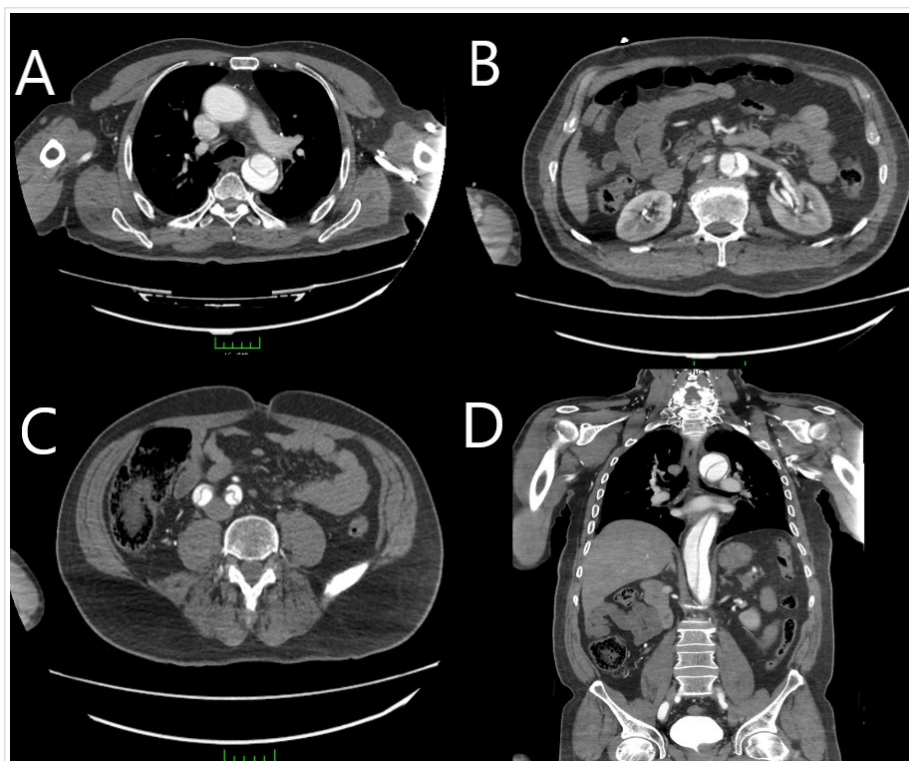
Image showing the descending aortic dissection (A), abdominal aortic dissection (B), and dissection in the bilateral iliac arteries (C), on transverse sections of thoracoabdominal contrast computed tomography. D. Preoperatively contrast-enhanced thoracoabdominal tomography shows dissection flap in descending aorta on sagittal sections.
